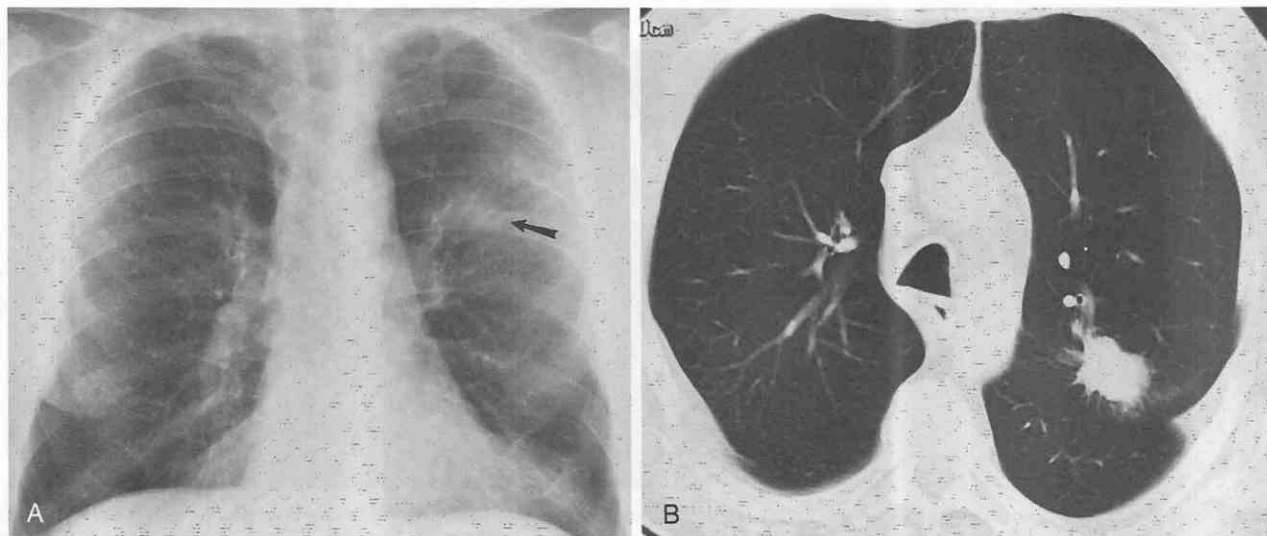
Bronchioloalveolar cell carcinoma seen as a solitary pulmonary nodule. *A*, Posteroanterior chest radiograph shows a nodule (arrow) in left upper lobe. *B*, CT scan reveals a spiculated margin suggestive of malignancy.
